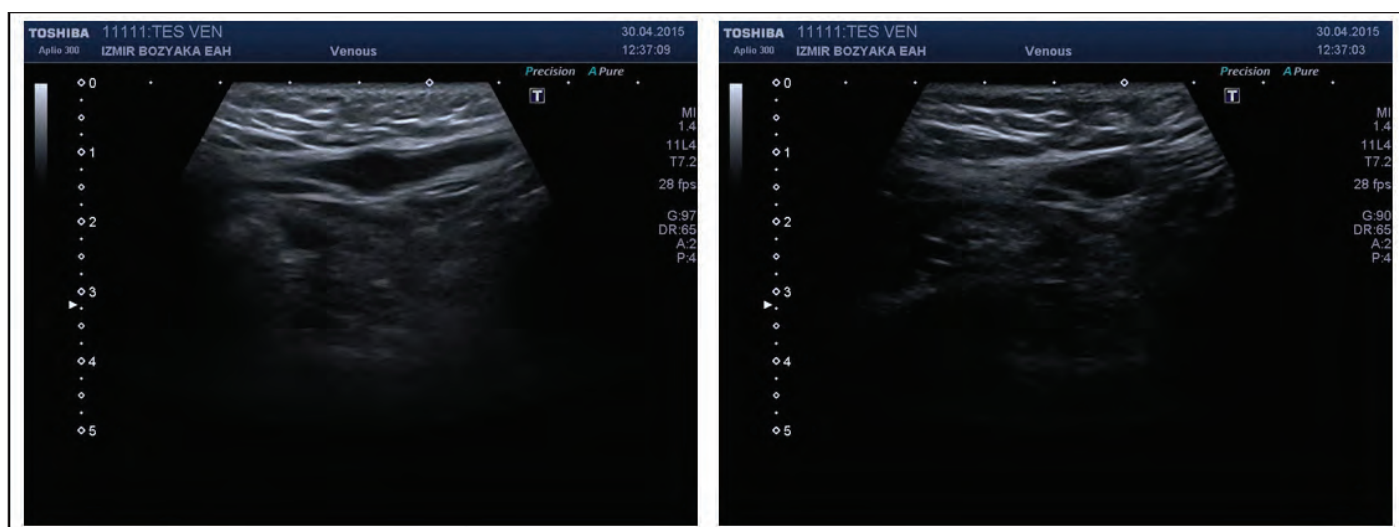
Grey scale ultrasonography demonstrated non-compressed thrombosed tubular venous structure with increased wall thickness and focal diameter increase within the right spermatic cord. Within this tubular structure, focal echoes that belong to thrombosis can be seen with an antero-posterior diameter 6 mm.
